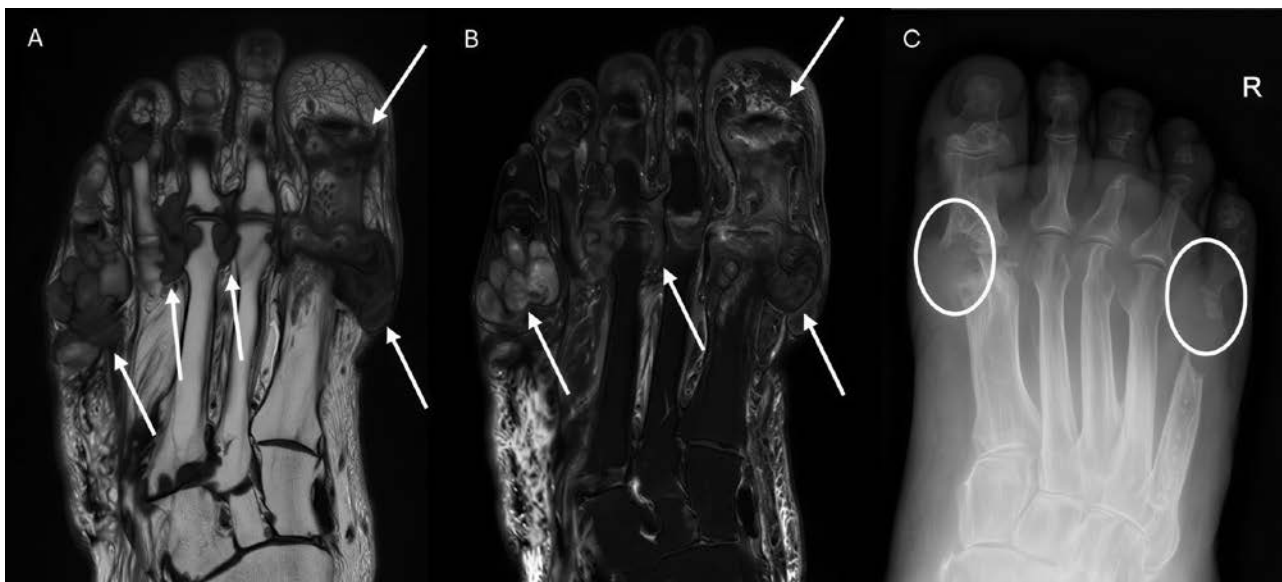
Coronal T1-weighted MRI (A) and Dixon water-only sequence (B) demonstrate extensive, lobulated periarticular soft-tissue deposits (arrows) involving multiple joints of the forefoot, with predominantly intermediate to low T1 signal and heterogeneous signal on fluid-sensitive imaging. The lesions show a typical periarticular distribution with associated soft-tissue swelling and edema. Conventional radiography (C) reveals characteristic punched-out erosions (circle) with overhanging edges. In contrast to TSGCT, these lesions do not demonstrate susceptibility-related blooming, while the presence of multifocal erosions and typical radiographic findings strongly support the diagnosis of gout.
